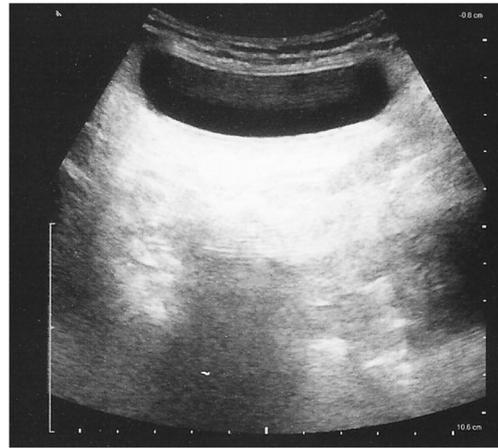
Sonographic appearance of a well-placed HSM reservoir performed during the first postoperative clinic visit
